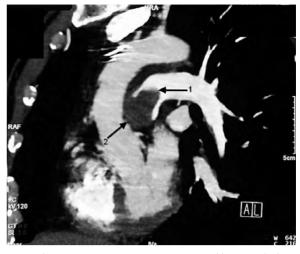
Pulmonary artery sarcomas in a 55-year old man with dyspnoea class II-III wrongly diagnosed as chronic thromboembolic pulmonary hypertension (CTEPH). Coronal enhanced computed tomography shows a filling defect occupying nearly the entire lumen of the main pulmonary artery (arrow 1), involving the pulmonary valves (arrow 2) and extending into the origin of left pulmonary artery (patient no. 8).
